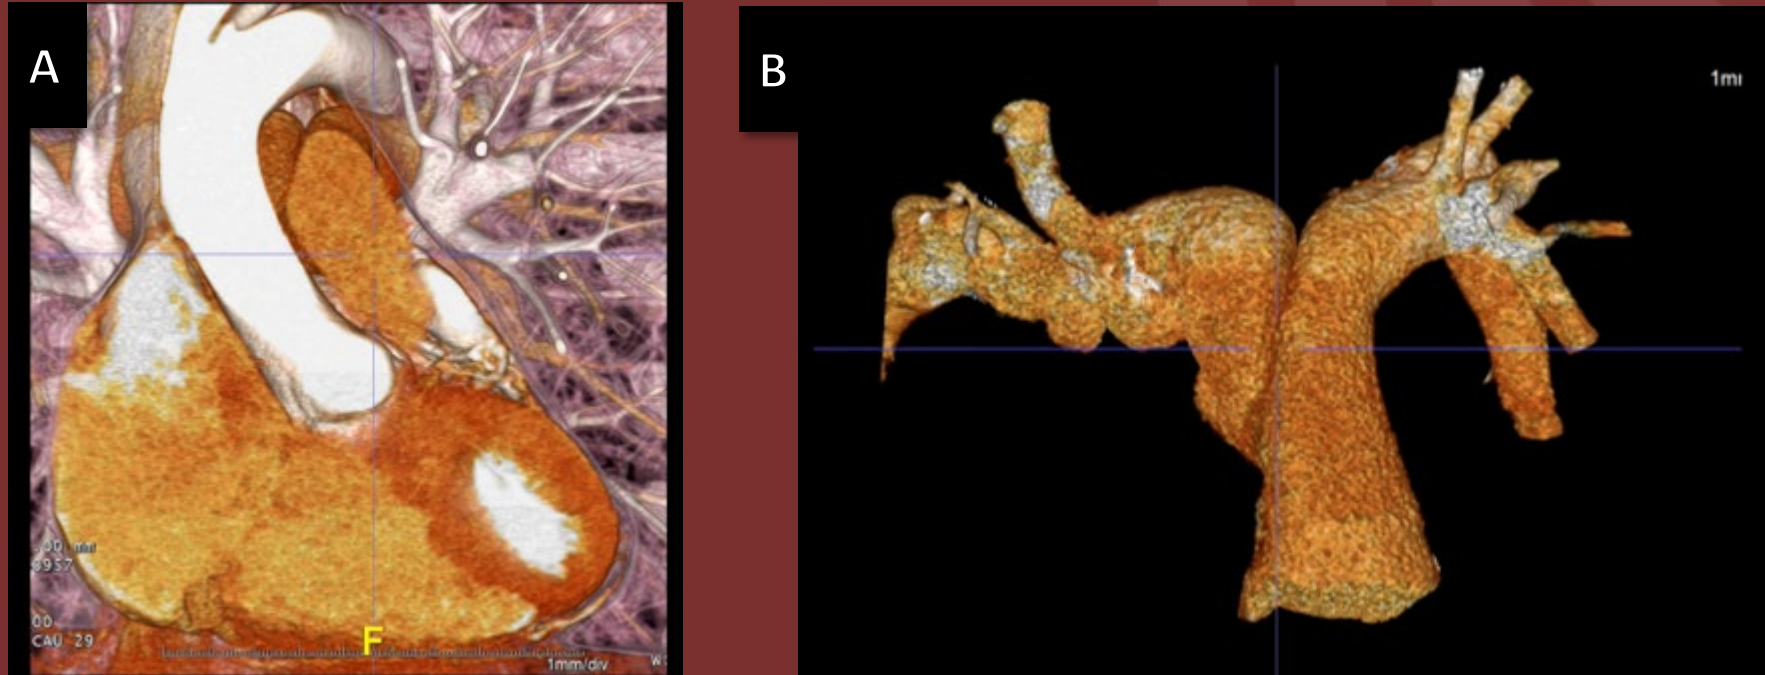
Cardiac CTA –Volume-renderings of the LVOT (A) and pulmonary arteries (B)
